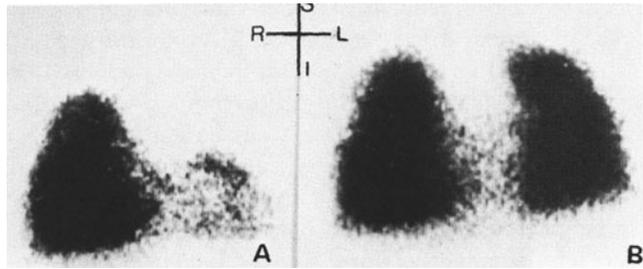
Case 4: (A) Preoperative pulmonary scintigraphy. No blood flow to the thrombosed left PA. (B) Postoperative scintigraphy showing good perfusion of the left lung after PA thrombectomy and MBS.
